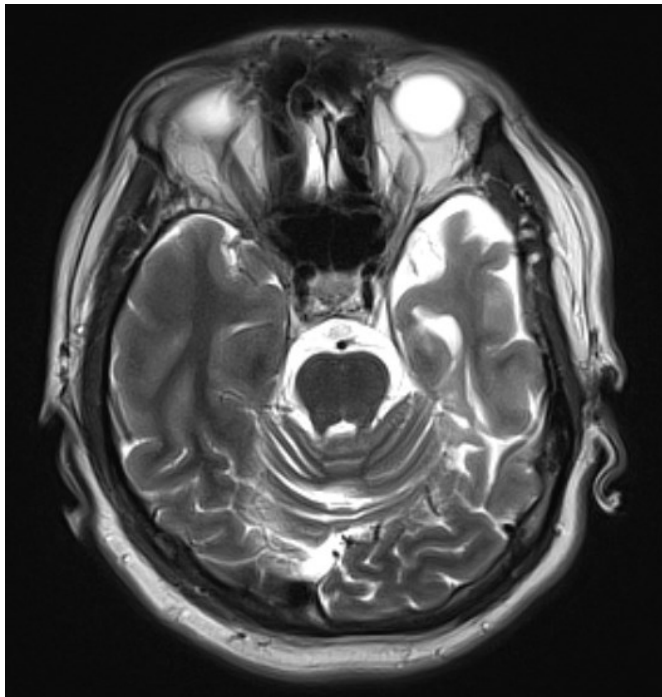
MRI scan, axial T2 sequence show left temporal lobe atrophy, with marked volume loss of the left hippocampus (structural cause for epilepsy)
